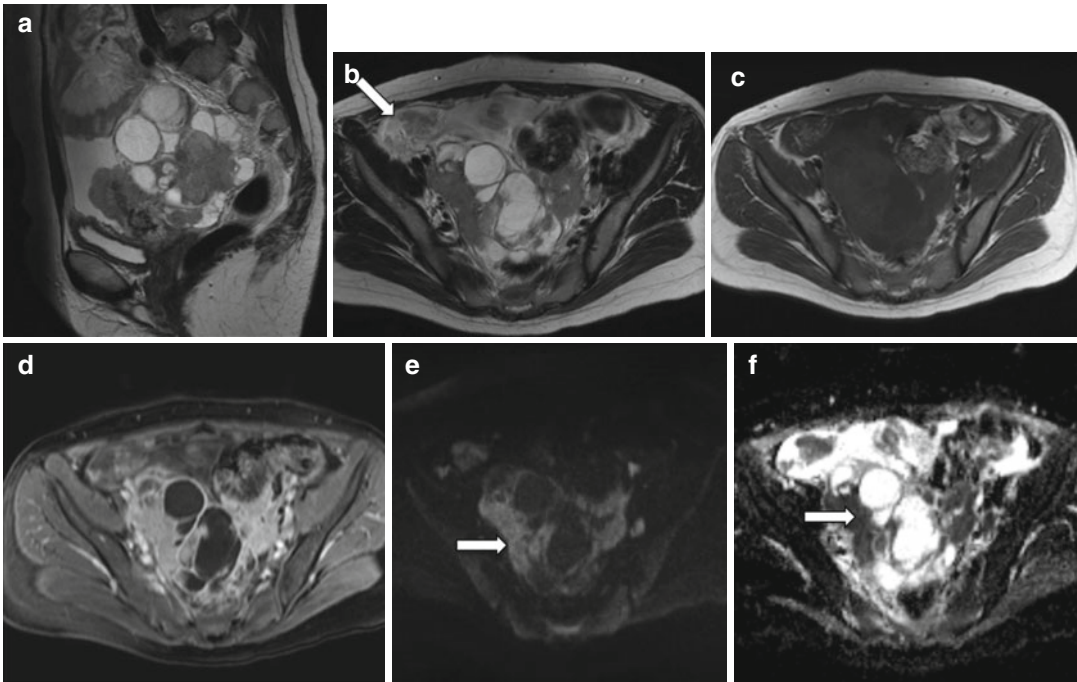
High grade ovarian serous cystadenocarcinoma. A 33-year-old woman with a rapidly enlarging pelvic mass and elevated CA125. Pelvic MRI demonstrates bilateral adnexal masses with solid components of intermediate signal intensity on T2-weighted images (TR:4361, TE:80; a, b) and predominantly low signal intensity on T1-weighted image (TR:519, TE:10; c). The
